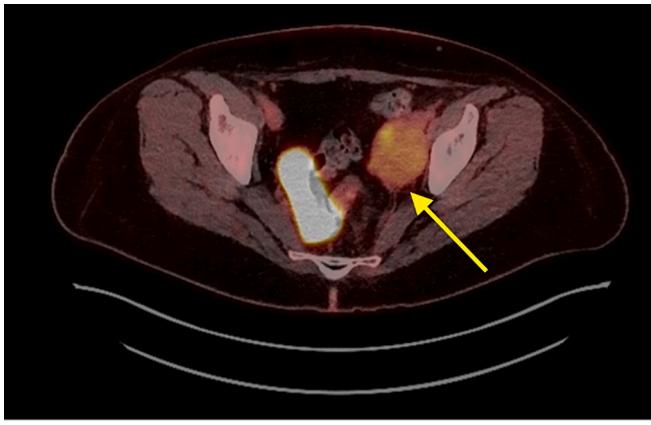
PET CT axial view-FDG avid mass along the left pelvic sidewall.
